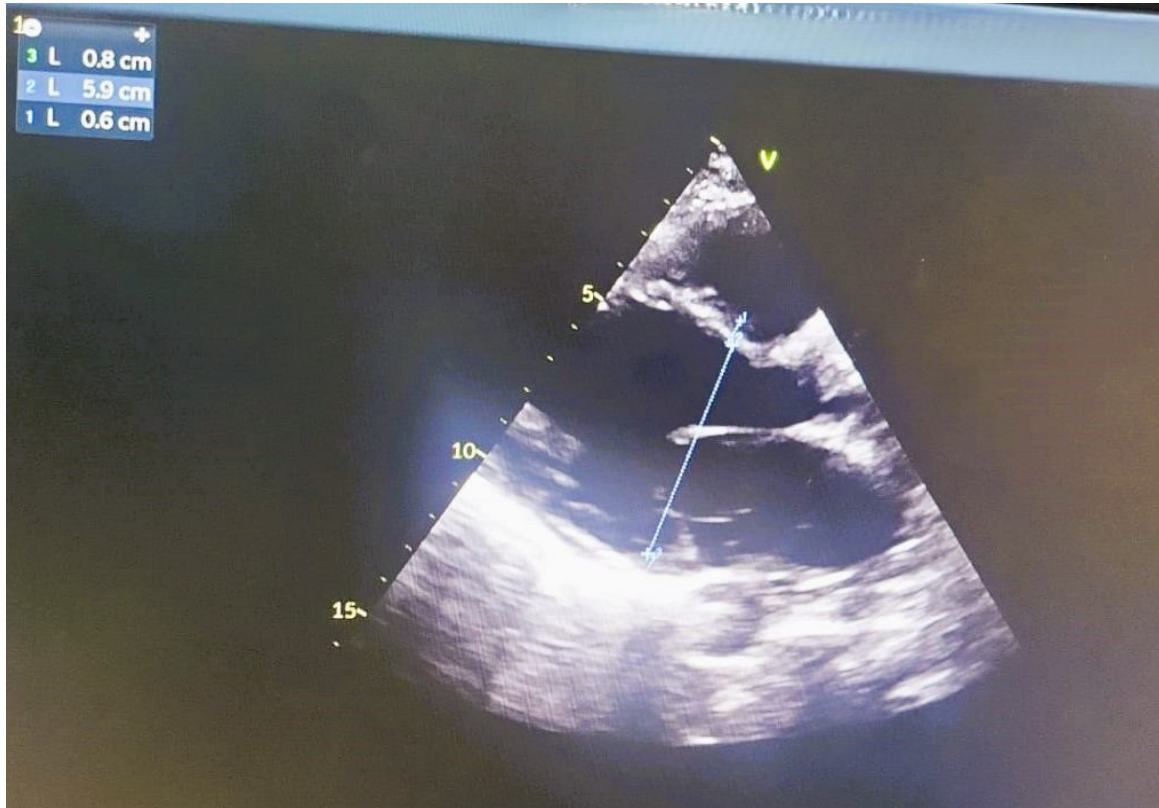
The ultrasound image demonstrates a dilated left ventricle.
